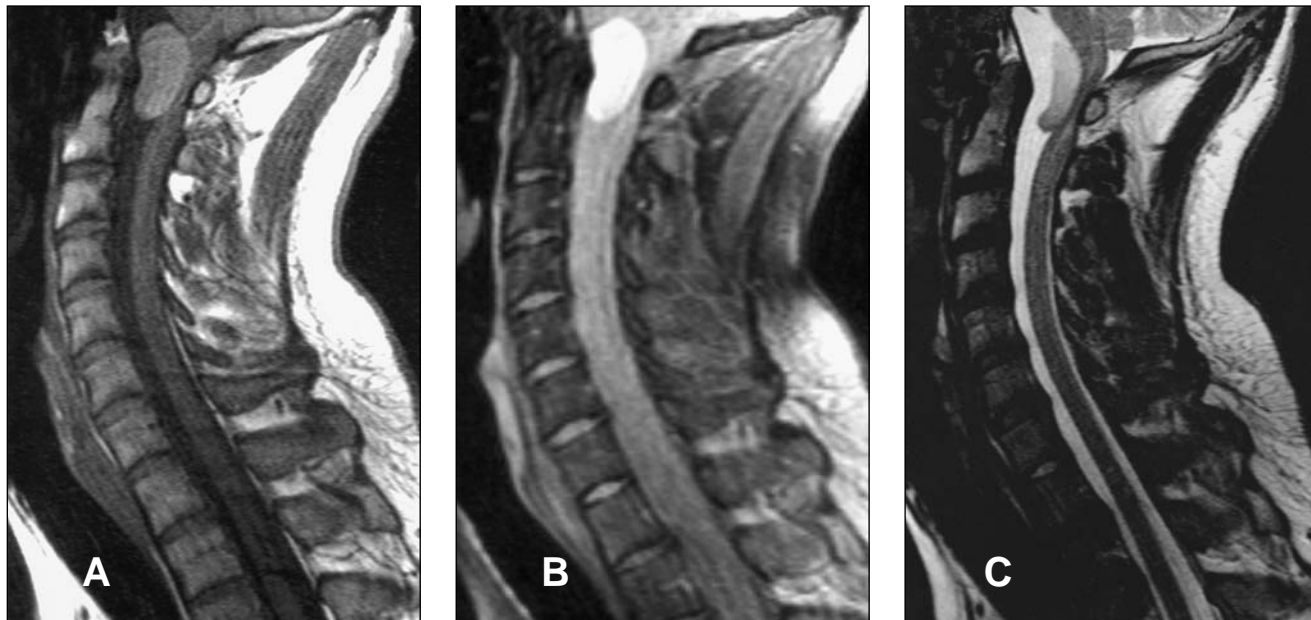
(A) Sagittal T1-weighted magnetic resonance imaging (MRI) scan (TR/TE, 500/15), showing a high signal intensity neurenteric cyst at the craniocervical junction with fluid-fluid level. (B) Sagittal proton density MRI scan (TR/TE, 2500/36), showing entire lesion to be hyperintense. (C) Sagittal T2-weighted MRI scan (TR/TE, 5420/96), showing nondependent, less proteinaceous component to be isointense to cerebrospinal fluid.
